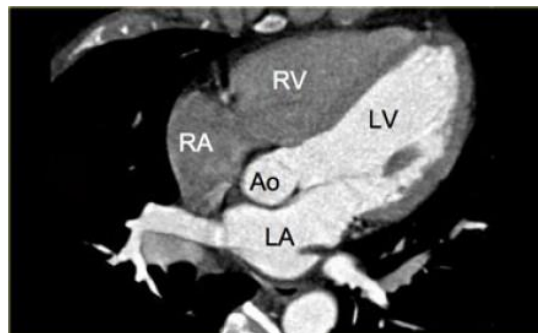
Cardiac CT. Right Atrium (RA), Right Ventricle (RV), Aorta, Left Atrium (LA), Left Ventricle (LV). Adapted from [29].
